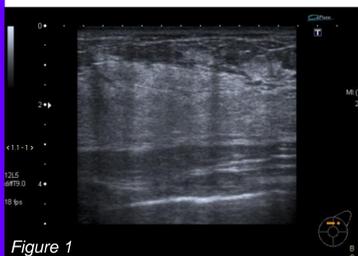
Ultrasound of symptomatic area showed subtle diffuse hyperechoic change.
